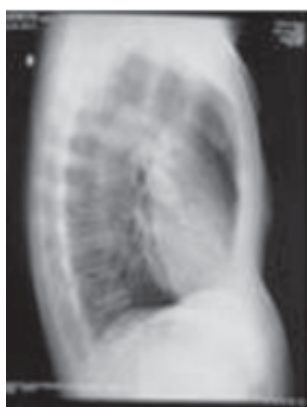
Profile chest X-ray at the first day of hospitalization.
